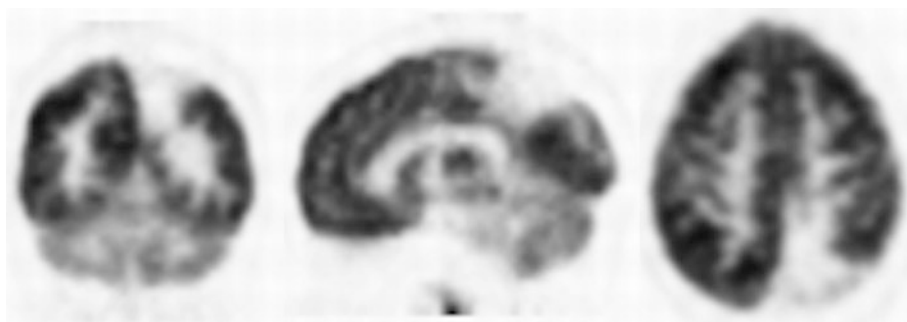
^{18}F -FDG-PET appearance in a patient with a rupture of an arteriovenous malformation
